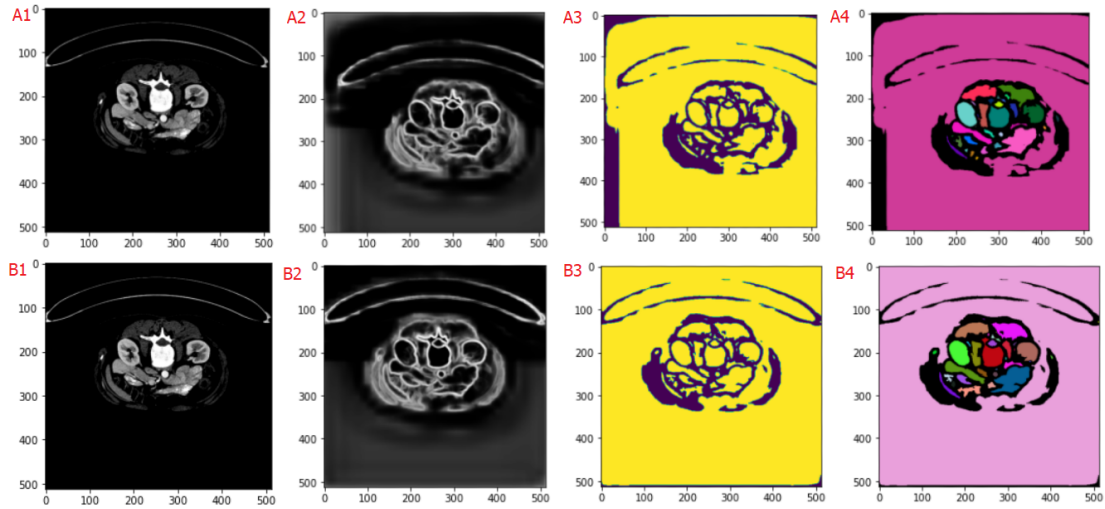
Cropping Layer implementation to the pancreas CT images. A1 (Uncropped) and B1 (Cropped) - Original Image, A2 (Uncropped) and B2 (Cropped) - blob (preprocessed image), A3 (Uncropped) and B3 (Cropped) - Segmented binary image, and A4 (Uncropped) and B4 (Cropped) - False colour image with a black background and coloured objects.
